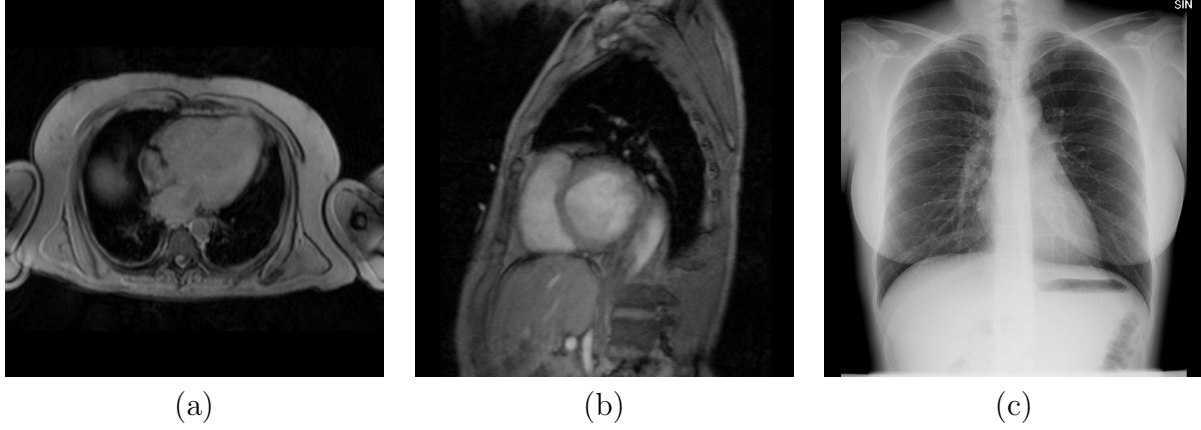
(a) A transaxial MR image of the thorax. (b) A short-axis MR image of the heart. (c) A frontal X-ray view of the thorax taken from a different patient.
